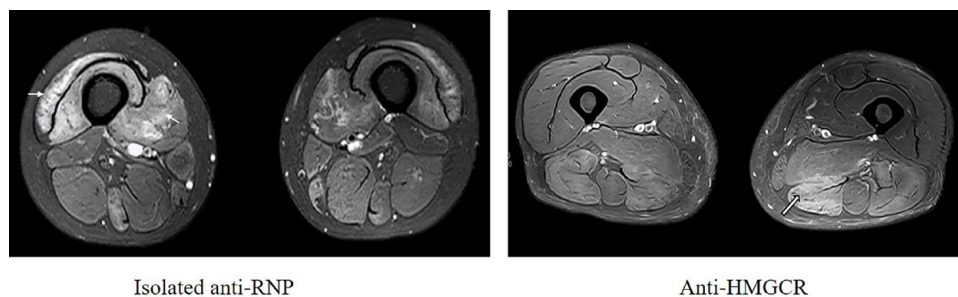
Abnormal signal intensity in skeletal muscle axial T2-weighted magnetic resonance imaging (arrow).
